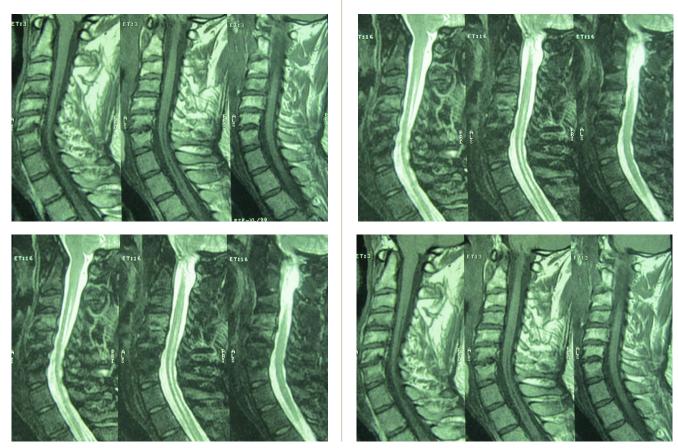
Case 1 – cervicothoracic sagittal T_1 - and T_2 -weighted magnetic resonance imaging shows syringohydromyelic cavity extending from C2 to T3, with type I Arnold-Chiari malformation.
